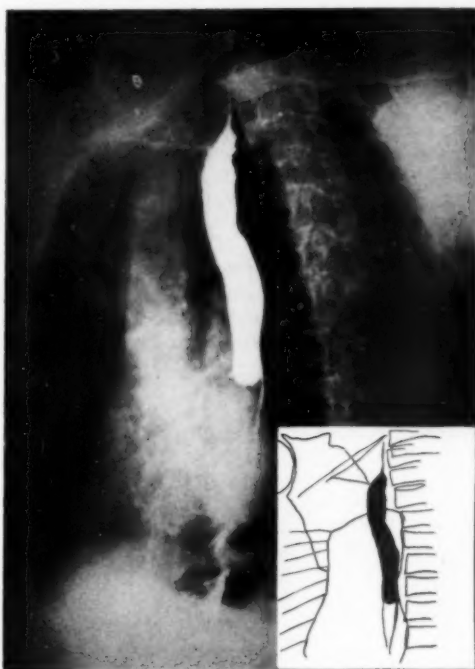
Left oblique roentgenogram. The displacement of the esophagus is less evident but it can be seen anterior to and above the aorta.
